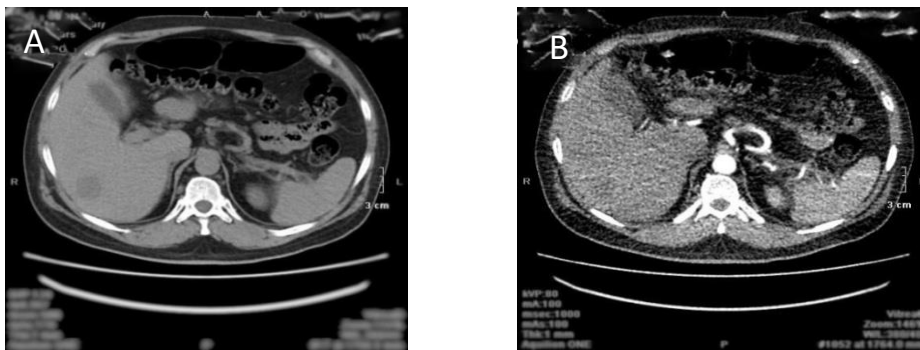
Explains the arterial and delayed phases in a triphasic CT study for hepatic focal lesion. It shows faint arterial phase of the segment VII right hepatic lobe focal lesion (A), with washout of contrast in the delayed phase (B).
